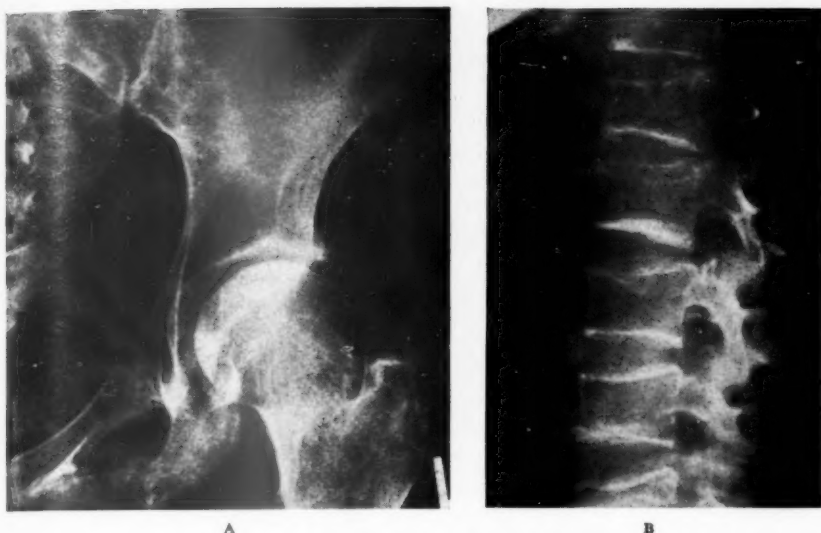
X-rays showing A fractures of the ischium and pubis, B osteoporosis of the lumbar vertebræ, with wedging and Schmorl's nodes.
